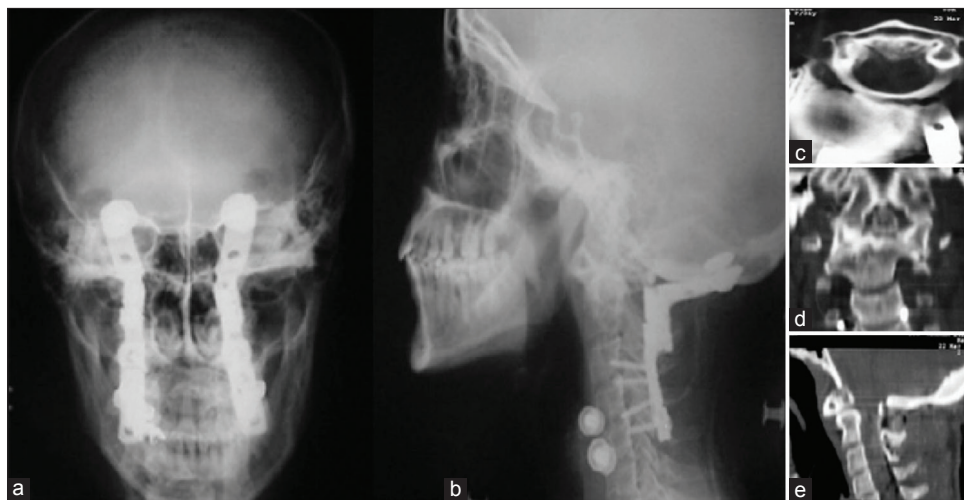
Postoperative radiographs of the patient who underwent surgery for occiput to C3 internal fixation by modified inside-outside occipito-cervical plate system. (a) Anteroposterior X-ray revealed stabilization with plate system (b) Lateral X-ray revealed appropriate anatomical contour of the plate system at the occipito-cervical junction. Occipital IO screws and lateral mass screws on cervical fusion levels are depicted. (c) Poststabilization axial computed tomography scans clearly depicted fixation of the occipito-cervical junction and decompression of the spinal cord. (d) Coronal reconstruction of the computed tomography scans depicted reduction of the dislocation after stabilization. (e) Sagittal reconstruction of the computed tomography scans depicted intact spinal canal with reduction at the level of C1–C2 after stabilization
